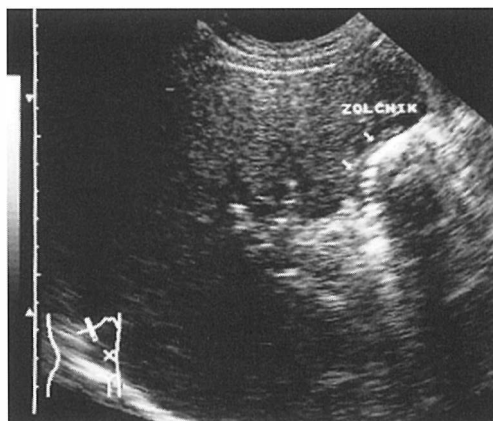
Ultrasonogram showing small, shrunken gallbladder with thickened wall and adhered firmly to the duodenum.
